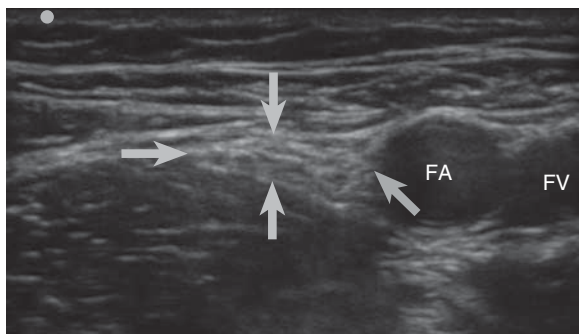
Ultrasound scan of the femoral nerve (labelled by the grey arrows) slightly distal to the inguinal ligament. FA, femoral artery; FV, femoral vein.
